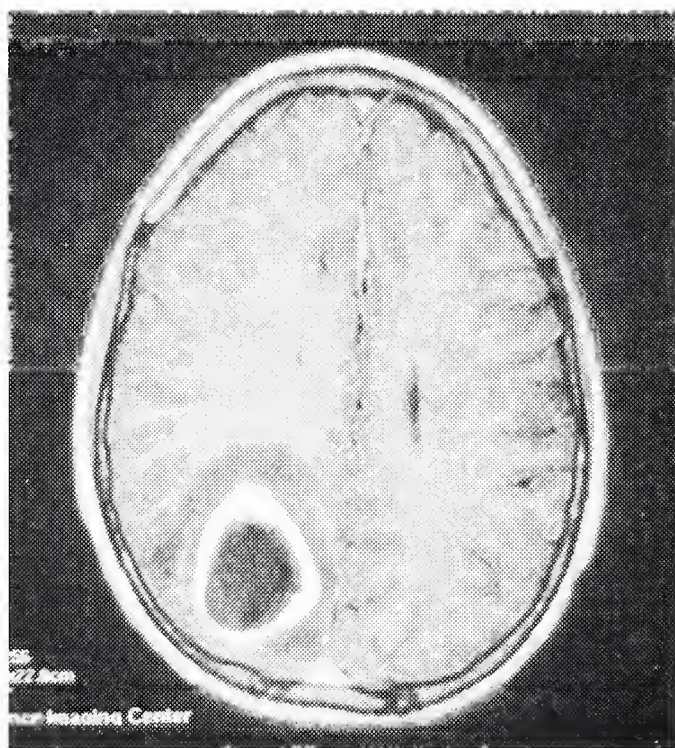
Saggital and Coronal and axial magnetic resonance image of the brain demonstrating a ring-enhancing lesion in the right posterior parietal / occipital region pre-operatively. continued on next page
